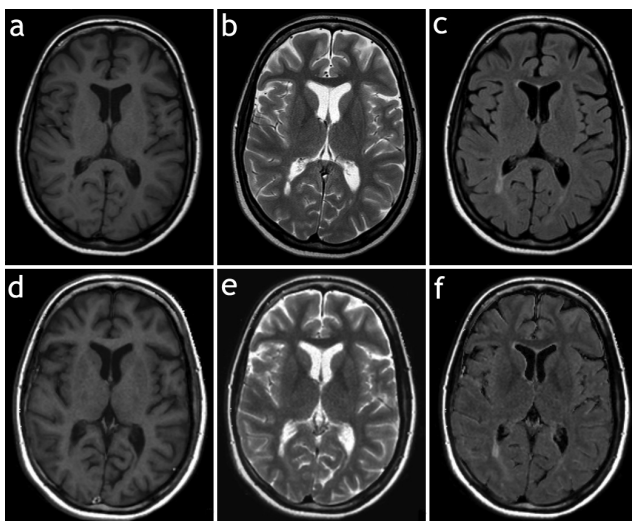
Example of an axial slice of the brain of a conventional T1W (a), T2W (b) and FLAIR (c) image. On the bottom row the corresponding synthetic images (d-f) are shown. All three synthetic images have been reconstructed using the same scan. The total scan time of the conventional images was 14:54 minutes, of the synthetic images 5:48 minutes.
